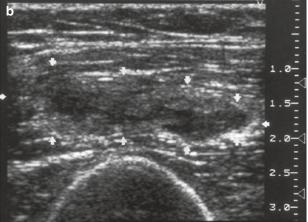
(\mathbf{a} - \mathbf{c}) Skeletal muscle hemangioma of vastus medialis muscle in young woman, who complained of swelling and vague pain. (\mathbf{a}) Axial fast spin-echo T2-weighted MR image. (\mathbf{b} , \mathbf{c}) Transverse US images. Well-defined, inhomogeneous, high signal intensity soft tissue structure in the medial vastus. (\mathbf{a}) A small amount
